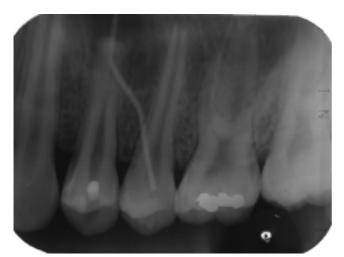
Radiograph of the upper left first premolar with guttapercha cone tracing.
